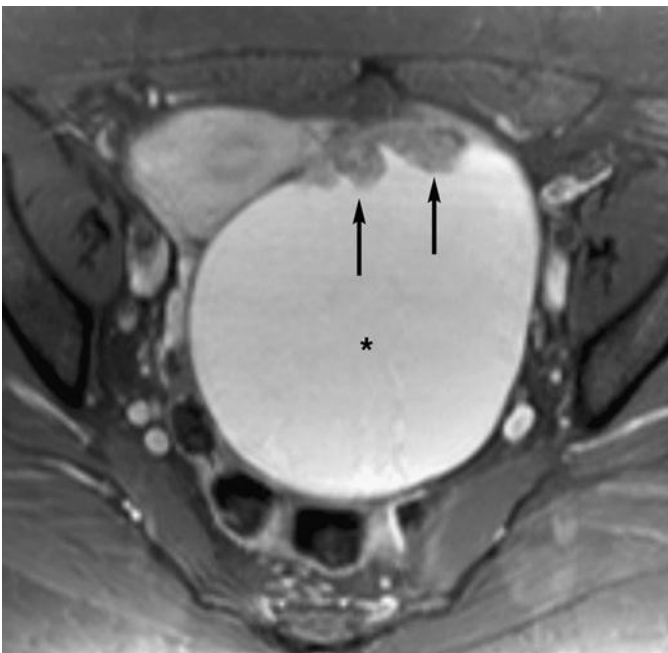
Clear cell carcinoma. Gadolinium-enhanced T1-weighted axial image with fat saturation. A large cystic mass (*asterisk*) that contains fluid of high signal intensity after fat saturation, consistent with blood, is seen within the pelvis. Enhancing mural nodules (*arrows*) anteriorly are suggestive of malignancy, and pathologic examination proved the lesion to be a clear cell carcinoma arising within an endometrioma.
